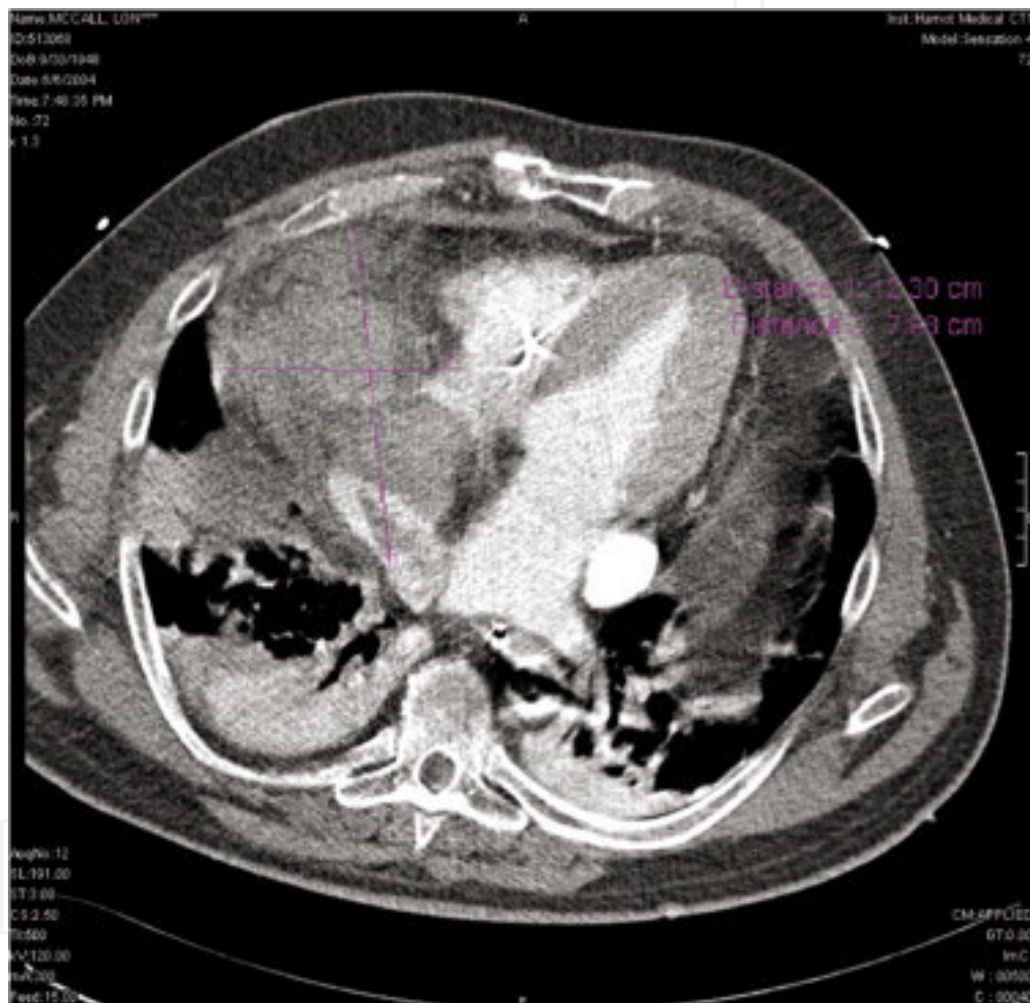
Chest CT scan image of a large leaking aneurysm compressing the right atrium
